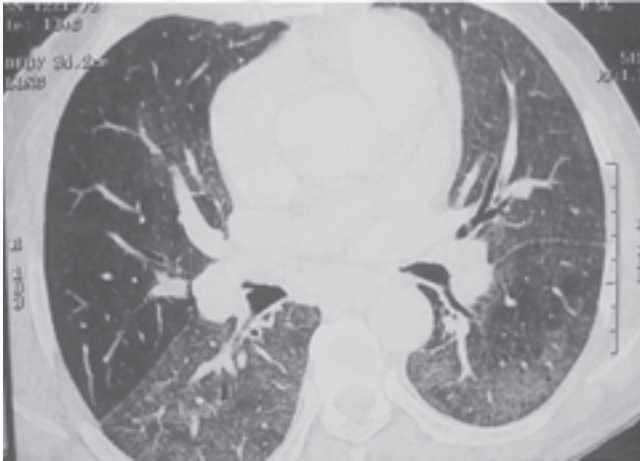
HRCT sections showing diffuse ground glass attenuation with relative sparing of right middle lobe.
